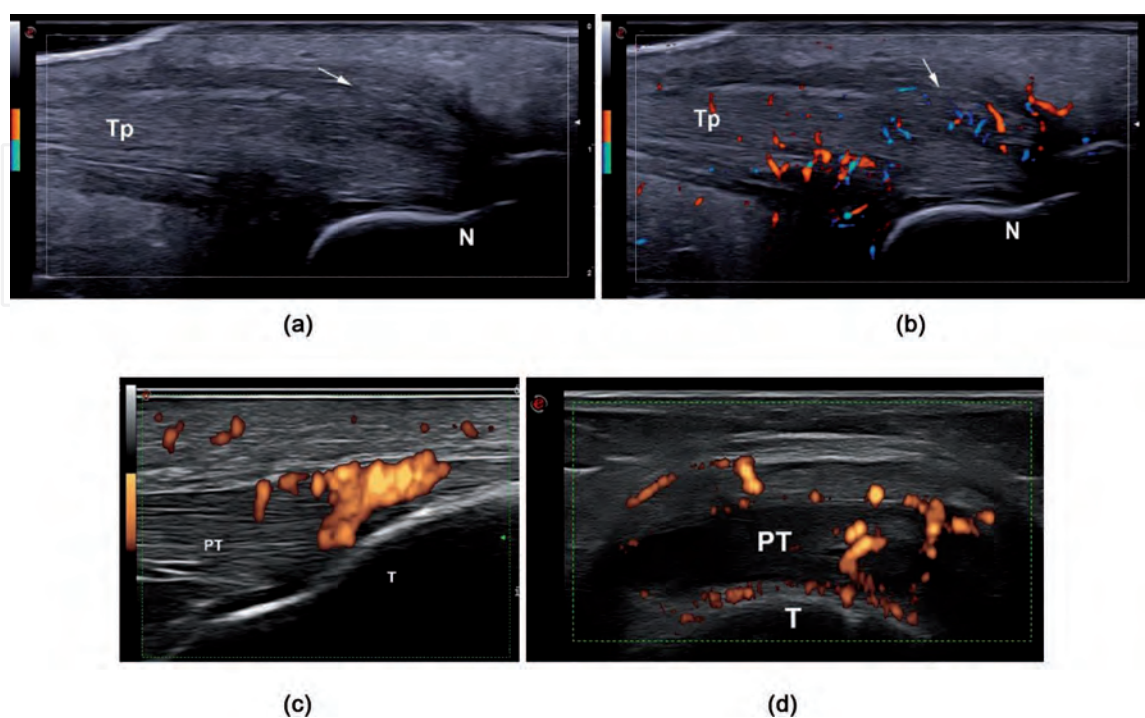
Ultrasonography of the tibialis posterior (a, b – Longitudinal aspect) (Tp) enthesitis (arrow) at the level of the navicular tuberosity (N) in GS (left) and power Doppler modes (right) and enthesitis of the patellar tendon (c – longitudinal, d – transverse). PT – Patellar tendon, T – tibia.
